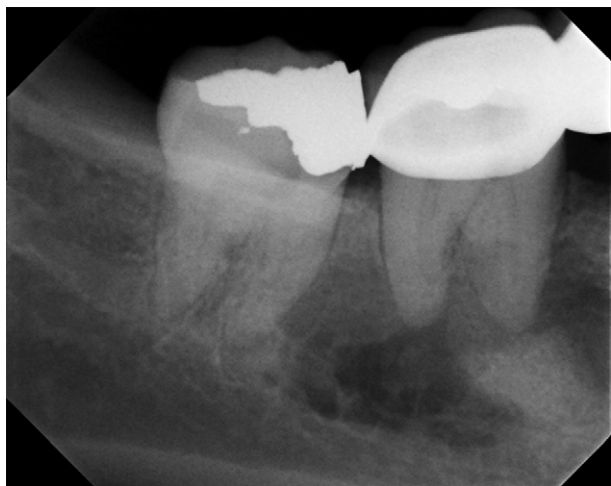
Initial periapical radiograph showing a mixed radiolucent and radiopaque lesion at the periapical area of the right mandibular second molar.
